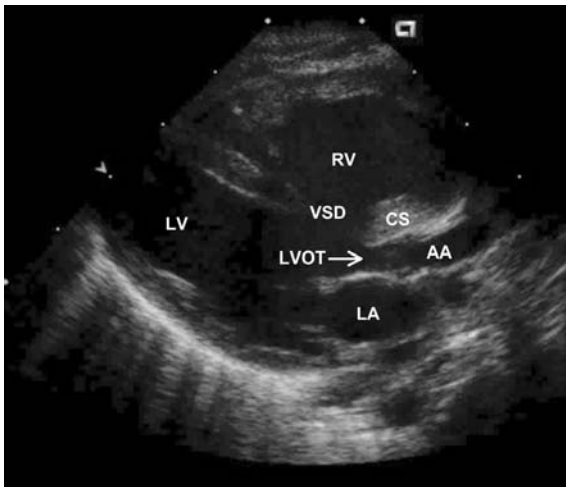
Echocardiogram of a patient with IAA. The conal septum (CS) is malaligned posteriorly creating a ventricular septal defect and obstruction of the left ventricular outflow tract (LVOT). AA ascending aorta, RV right ventricle, LV left ventricle, LA left atrium
